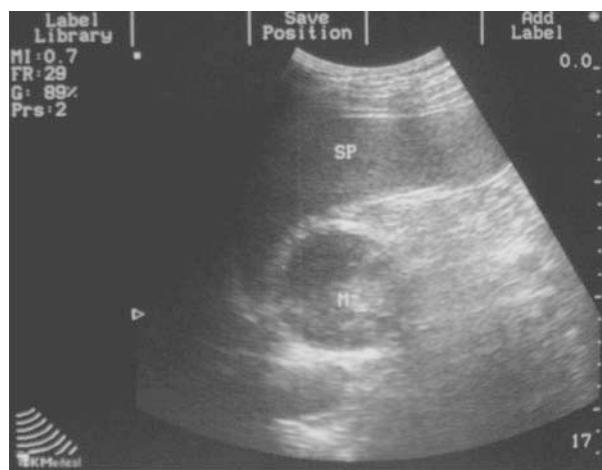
Ultrasonographic images of the left abdomen showing a well-circumscribed hypoechoic mass with cystic components measuring 6 cm in diameter.
